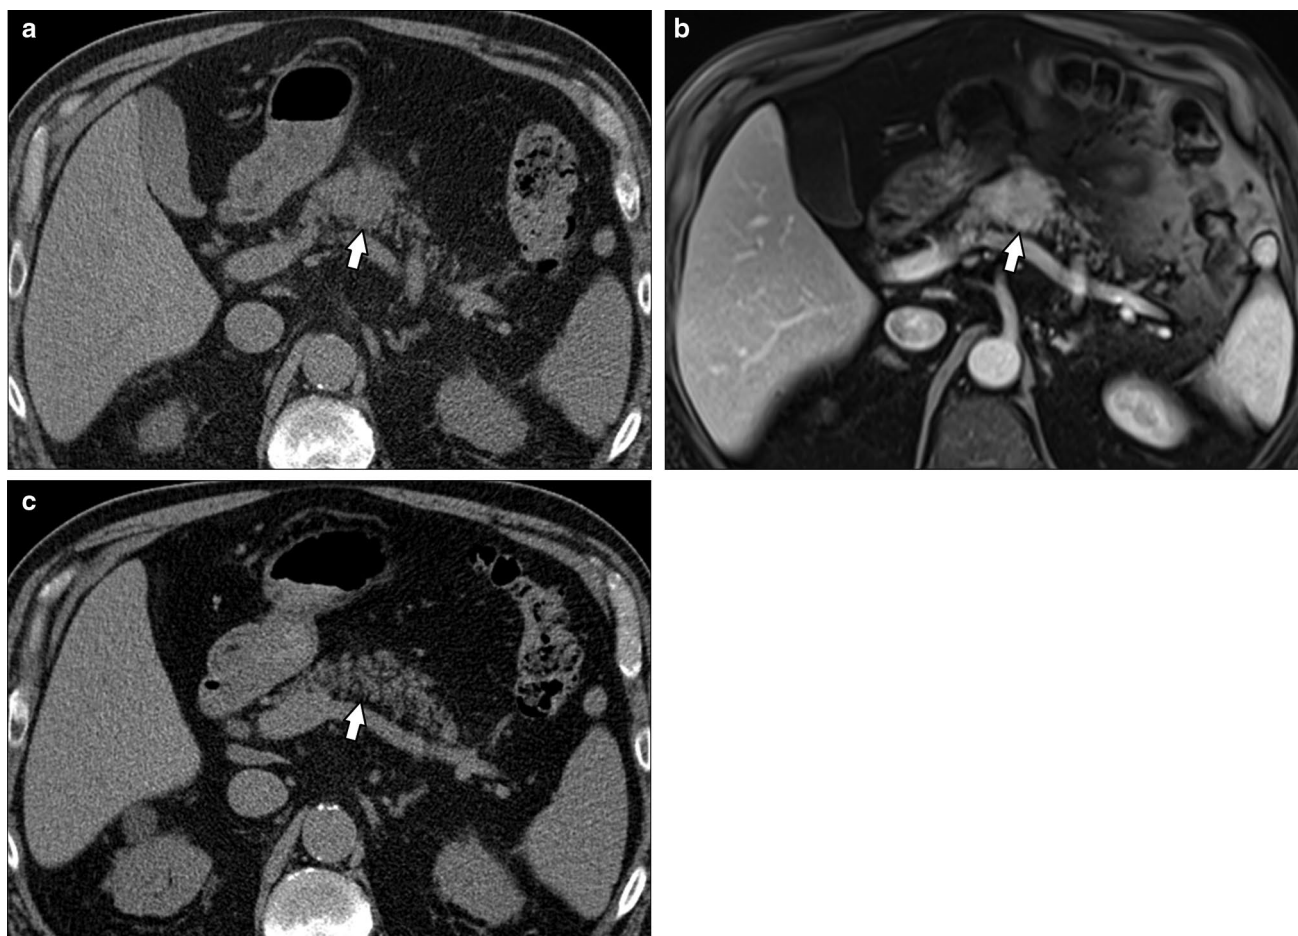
A 72-year-old male with pancreatic mass incidentally found on chest CT and normal serum IgG4. a Axial unenhanced CT image shows mass-like lesion in the pancreatic body (arrow) prompting further evaluation with MRI. b Axial T1 FS portal venous phase MR image shows an enhancing lesion (arrow), corresponding to finding
